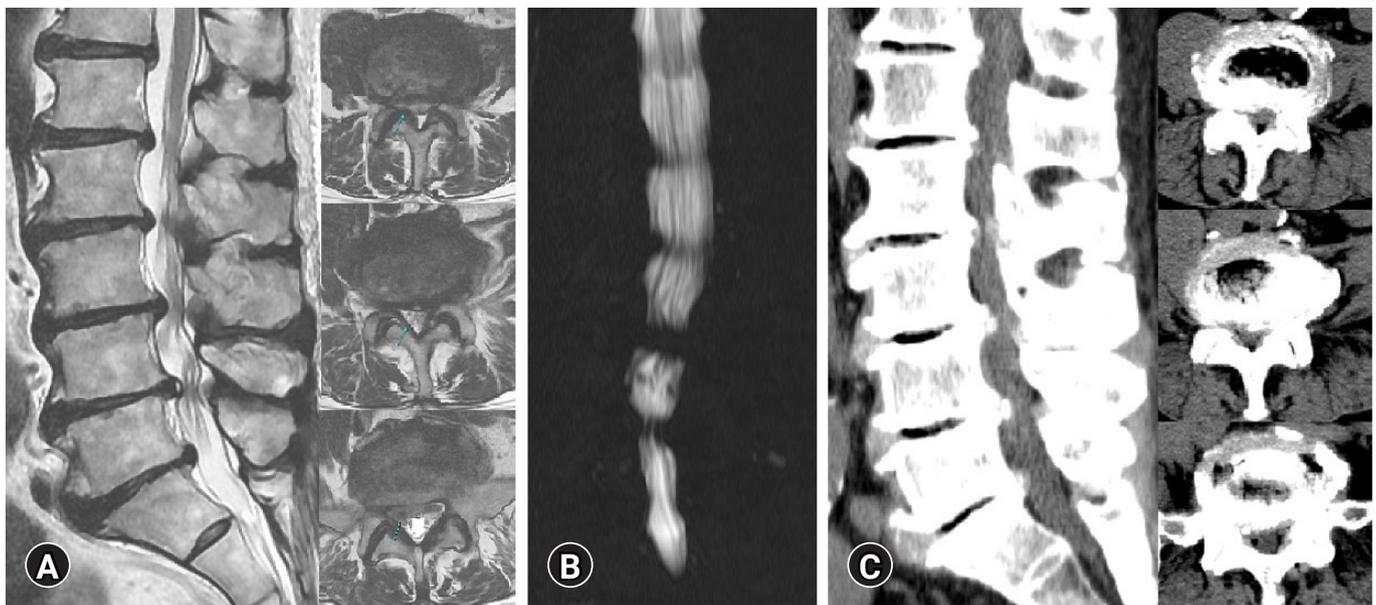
Preoperative images of lumbar spinal stenosis at L3-4, 4-5, 5-S1 level on MRI, MR myelography, and CT. (A) Sagittal and axial images on T2 weighted MRI. (B) An image on MR myelography. (C) Sagittal and axial images on CT.
